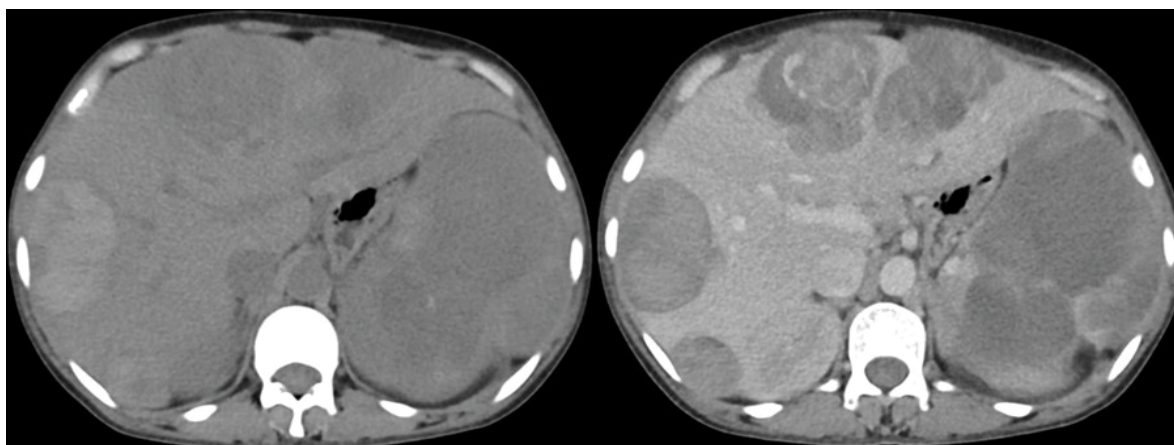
Primary Hepatic Angiosarcoma. Plain (a) and contrast enhanced CT (b) axial sections shows heterogeneous density lesion with necrotic areas and hemorrhagic foci within seen arising from spleen. Similar appearing lesions seen involving both lobes of liver. No significant post-contrast enhancement seen within the lesion.
